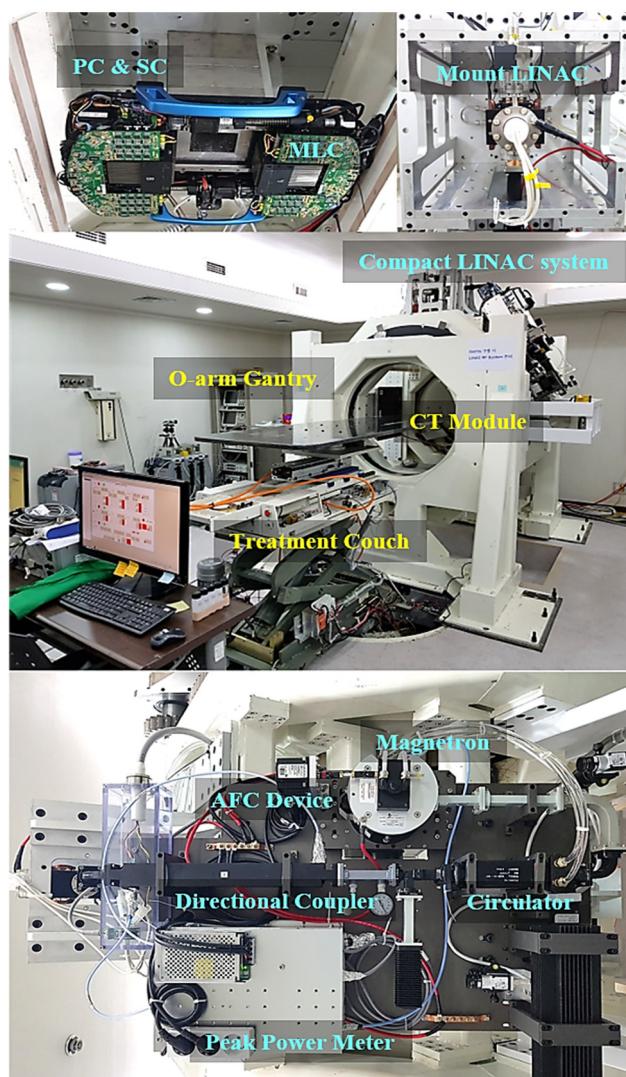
Combined radiotherapy with O-arm CT.
